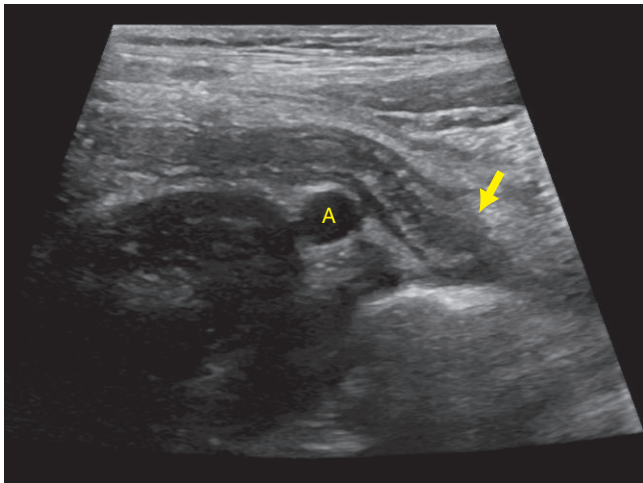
Ultrasound of the right lower quadrant of the abdomen revealed a blind ending tubular structure (arrow) that was compressible and corresponds to the appendix. (A=external iliac artery.)
